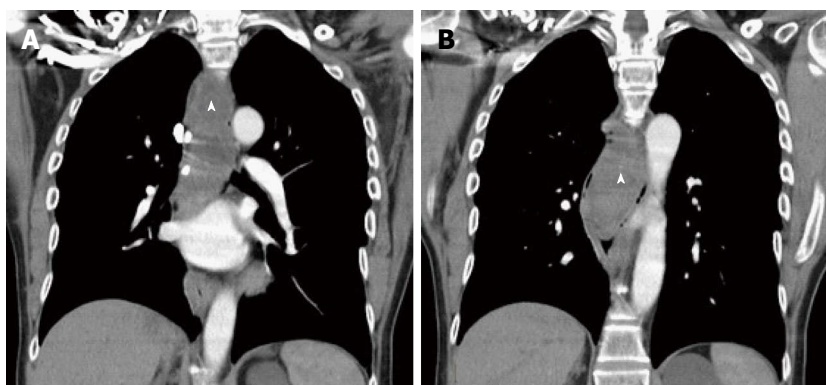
Computed tomographic scan of the chest (A) (B) showing a (arrowhead) large mass traversing the length of the esophagus.
